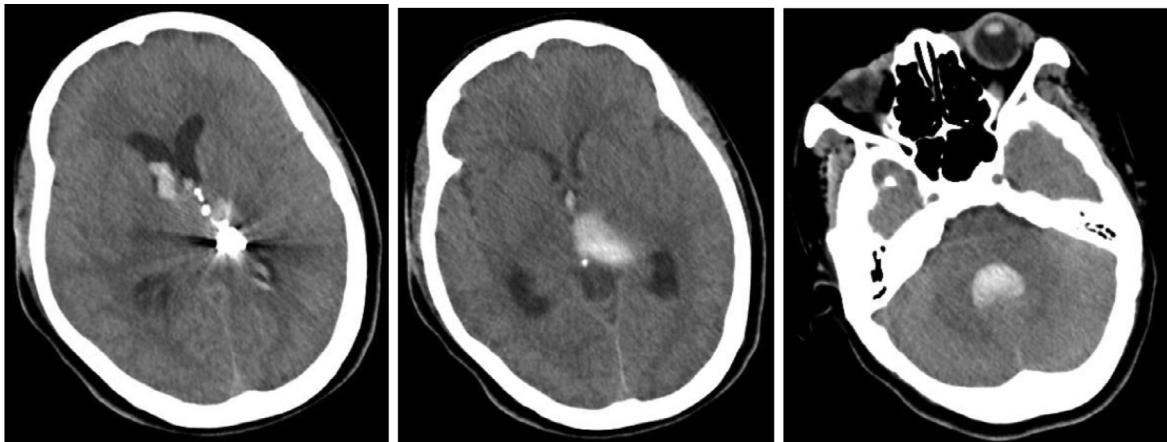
CT scan of the brain 1 day after the intervention showed a slight increase in blood count in the left thalamus and fourth ventricle.
